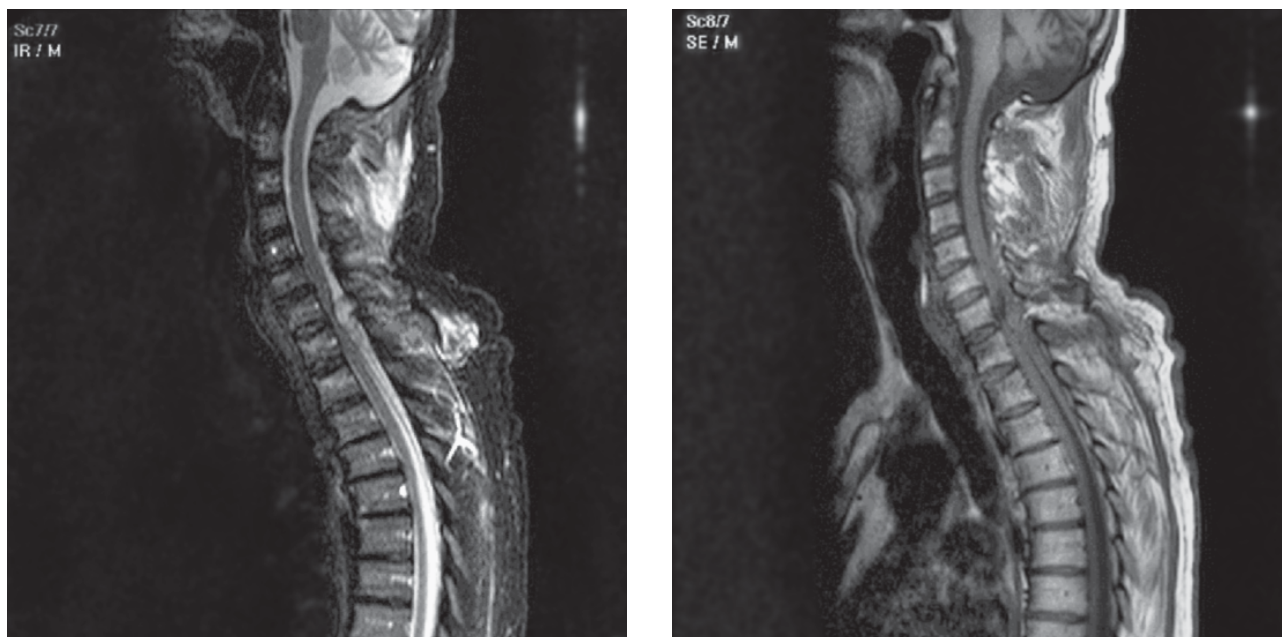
Magnetic resonance imaging studies. Left: Sagittal T2-weighted image obtained on the day of hospital admission. A heterogeneous biconvex lesion at the C7-T1 level posterior to the spinal cord producing compression of the sac. Right: T1-weighted image obtained in the same patient.
